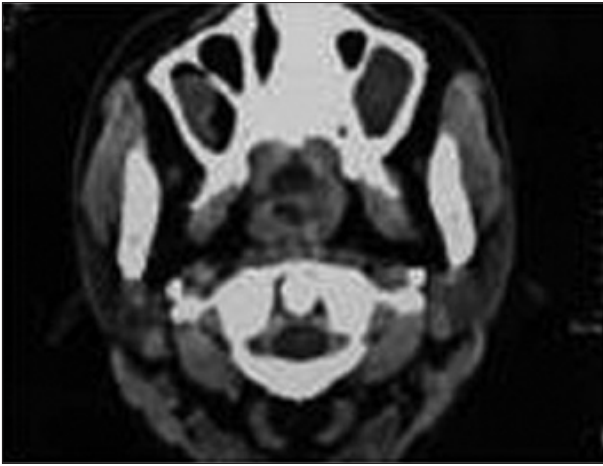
CT scan showing narrowing of the oropharynx due the membrane (shown by arrow)
